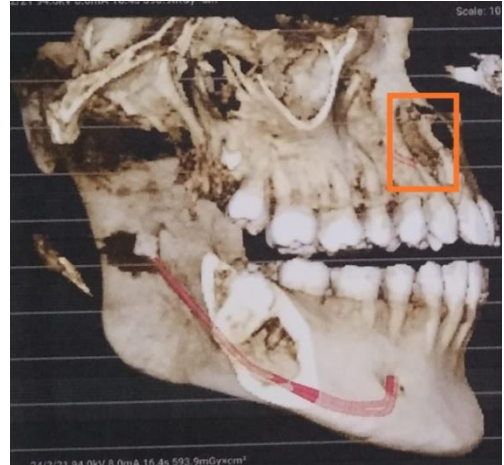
CBCT showing depth of the lesion in 3D view.
